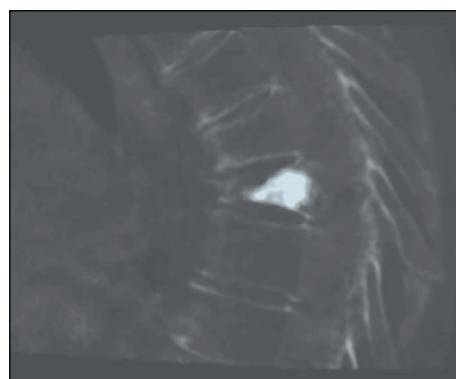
Postprocedure cone-beam CT sagittal reformat image showing adequate cement placement in the T10 vertebral body.
